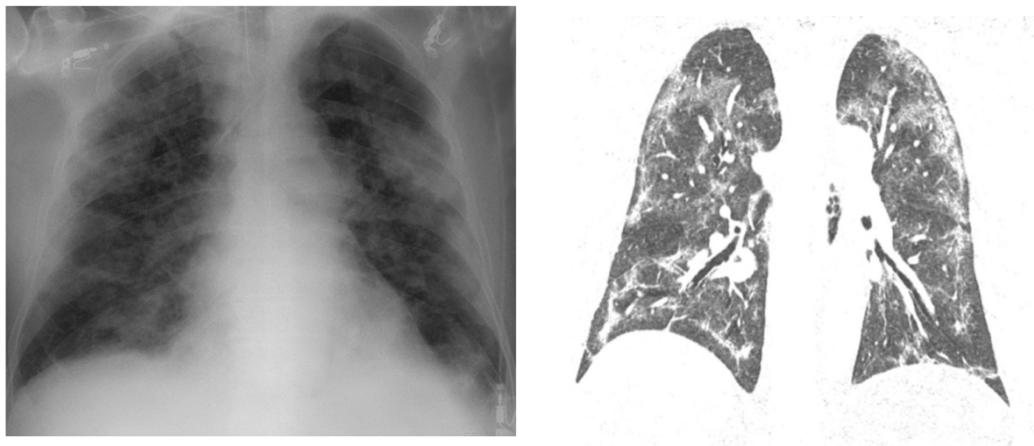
Chest X-Ray and CT images of a Sars-CoV-2 patient (Long et al, 2022).
